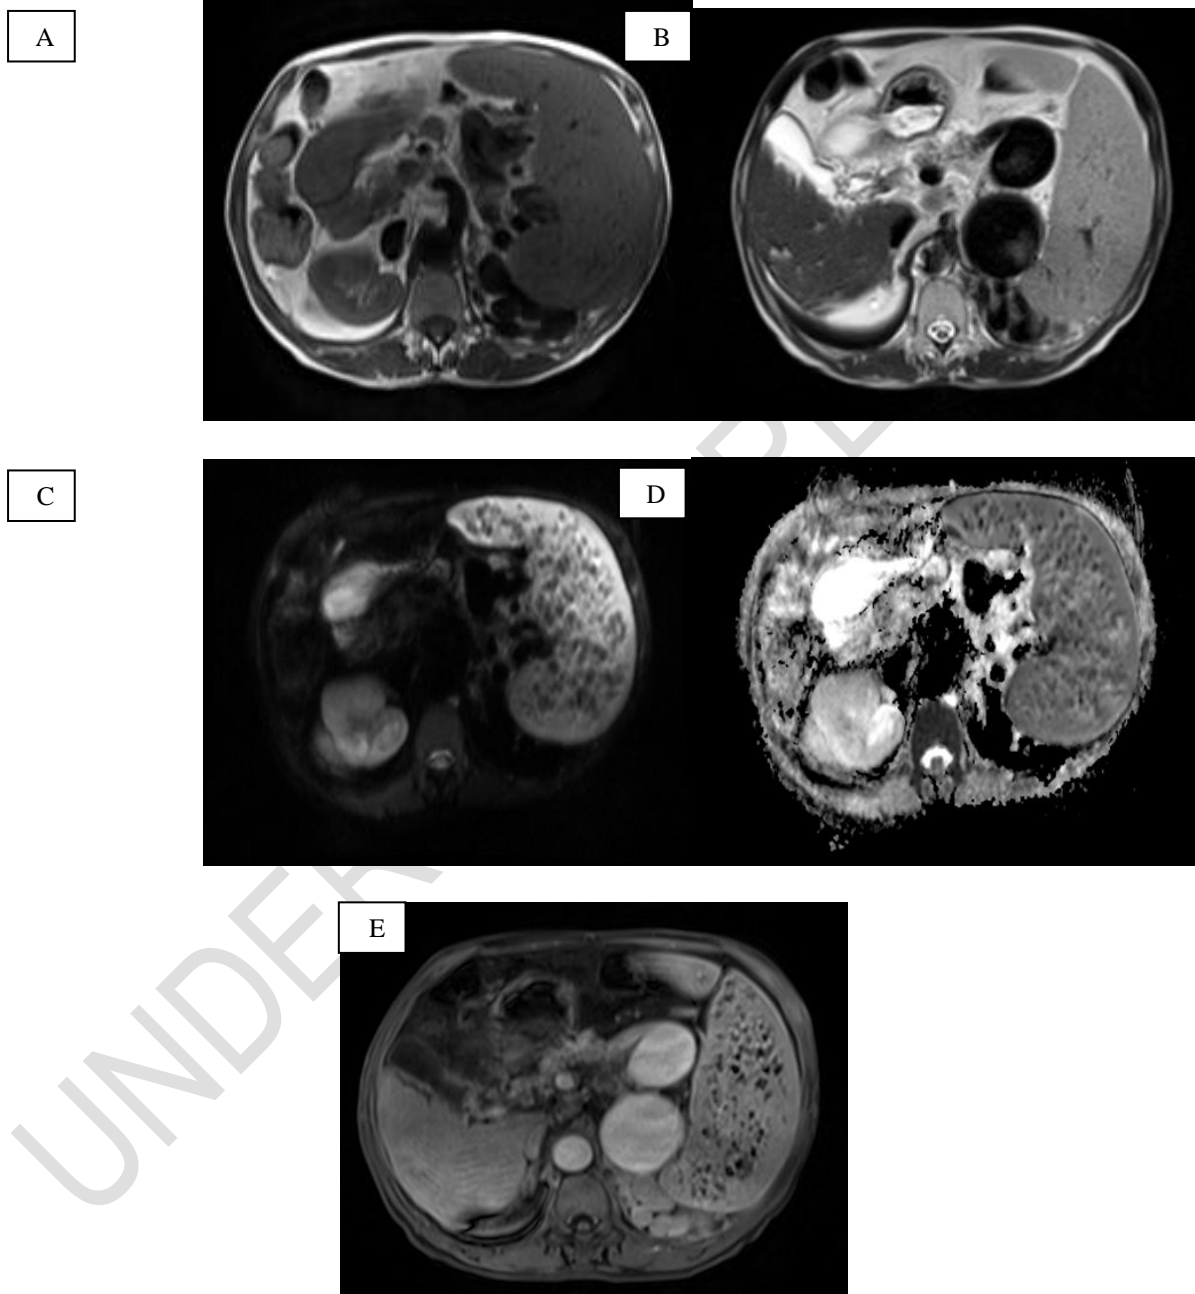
Axial T1WI, Axial T2WI, DWI, ADC Map, Post contrast T1WI, and Axial T1WI(A) revealed enlarged spleen measuring around 20 cm in its maximal bipolar span with numerous small foci of low signal on both T1WI(A) and T2WI. Free diffusion was visible in the lesion. Absence of post-contrast enhancement evidence. Based on the MRI results, the diagnosis of gandy gamma bodies was made.
